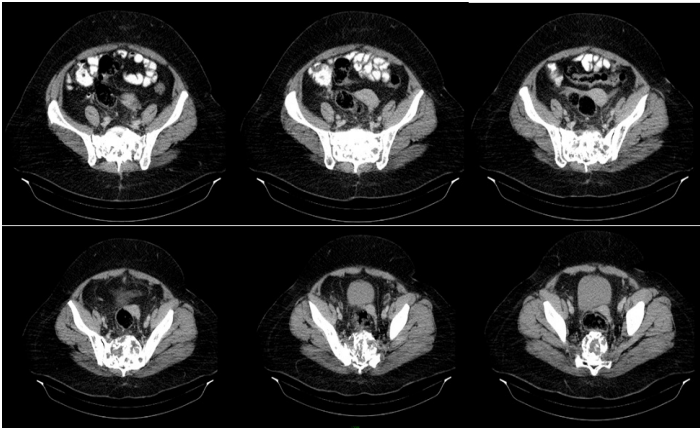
CT of the sacrum after 3 years from definitive radiotherapy up to TD 64 Gy combined with targeted therapy.
